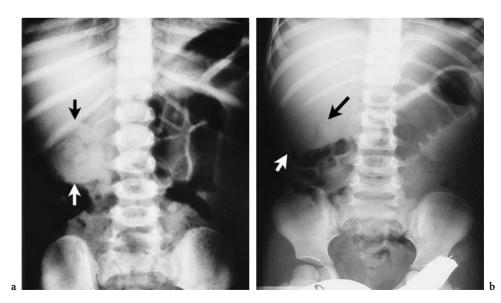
Target sign. a,b Two different patients. Plain radiographs show a round soft-tissue mass in the right upper quadrant (*arrows*). The masses contain a ring-like area of lucency [From DEL POZO (1999)]
